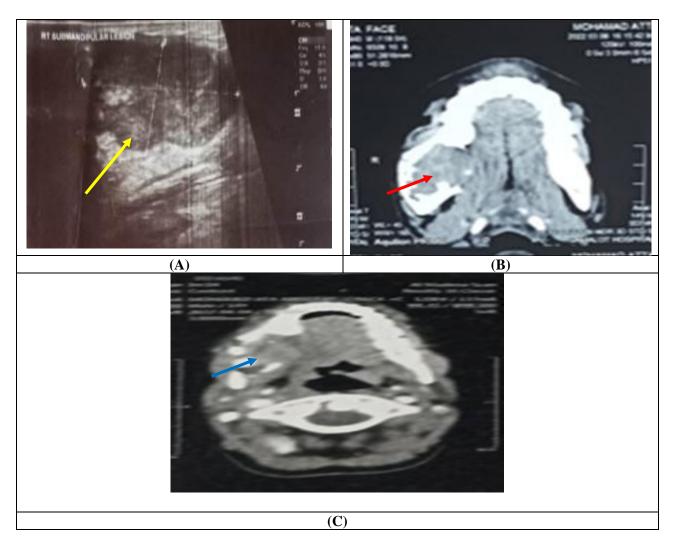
14 years male patient complained of painless swelling in right mandibular region 2 years ago, neck ultrasound done showing multiple well defined hypoechoic pathologically enlarged lymph nodes all are losing the fatty hulium and rounded seen upper deep cervical, sub mental and sub mandibular region (A yellow arrow), CT neck with IV contrast showing well defined right submandibular soft tissue mass lesion with bony extensions seen involving the right submandibular gland and right ramus of the mandible seen reaching the alveolar process with erosions of related cortex, mainly the medial cortex with intraoral extensions with post contrast heterogeneous enhancement. (B without contrast red arrow) (C with contrast blue arrow), diagnosed as right sub mandibular malignant lesion and final diagnosis was right sub mandibular lesion keeping with low grade mucoepidermoid associated with fibro epithelial polyp.
